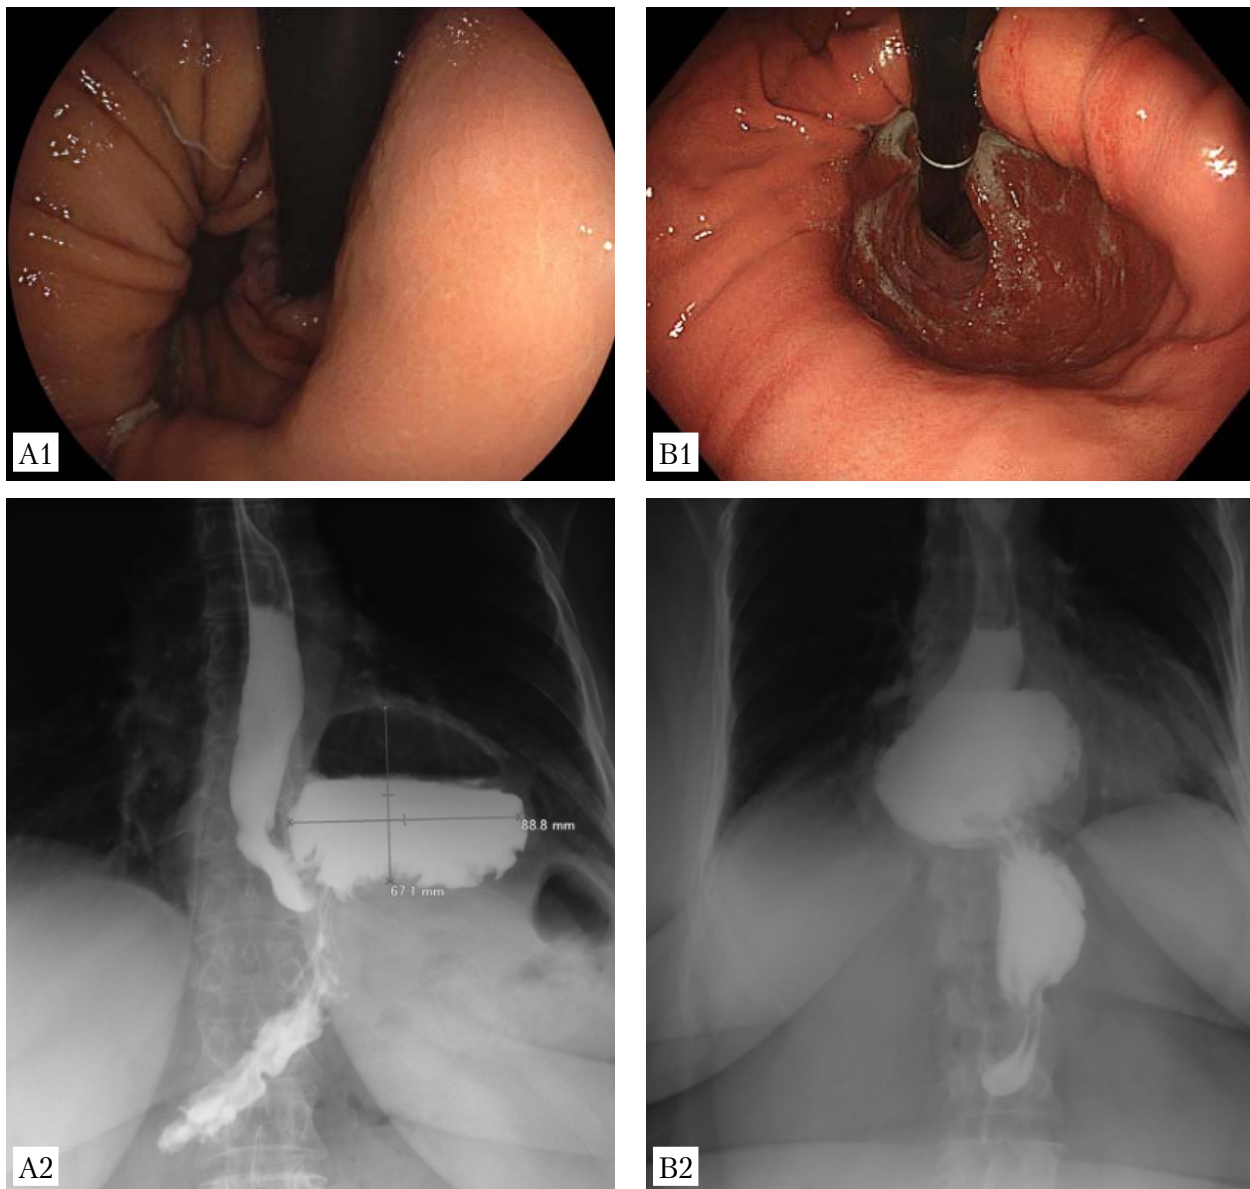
Endoscopic and X-ray results for paraesophageal hernias. A1, B1 – examination of the esophageal hiatus in inversion; A2, B2 – esophagogastrography with the barium. A1, A2 – patient D: the esophageal hiatus is located distal to the upper border of the hernia sac. B1, B2 – patient C: the esophageal hiatus is located proximal to the upper border of the HS
